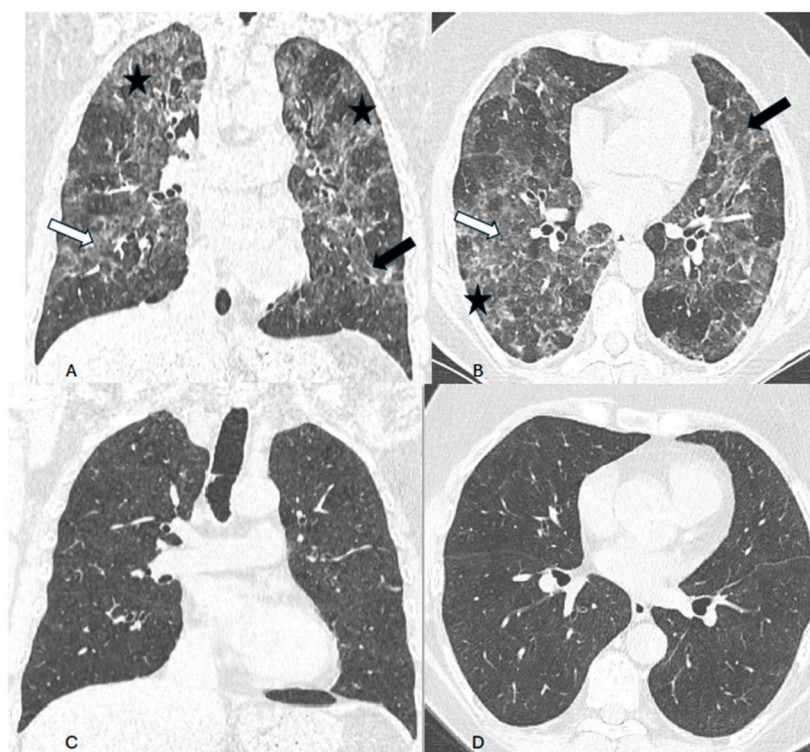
Patient 3 - HRCT scan coronal and axial planes. A, B – baseline scans: In the whole lungs bilaterally diffuse nodular consolidations (black arrows) and ground glass opacities (white arrows), with the reticulation pattern in peripheral lung regions with signs of lung fibrosis (asterisk). C, D – follow-up scans: Complete regression of pulmonary infiltrates and no signs of lung fibrosis.
